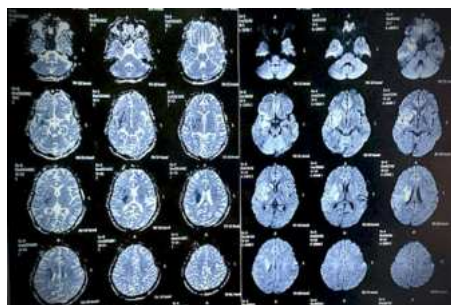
Axial T1 and sagittal weighted images of the 16-year-old girl. The regions corresponding to T2/FLAIR hyperintensities are hypointense on T1 weighted images. Sagittal T2 images show concordant findings.
